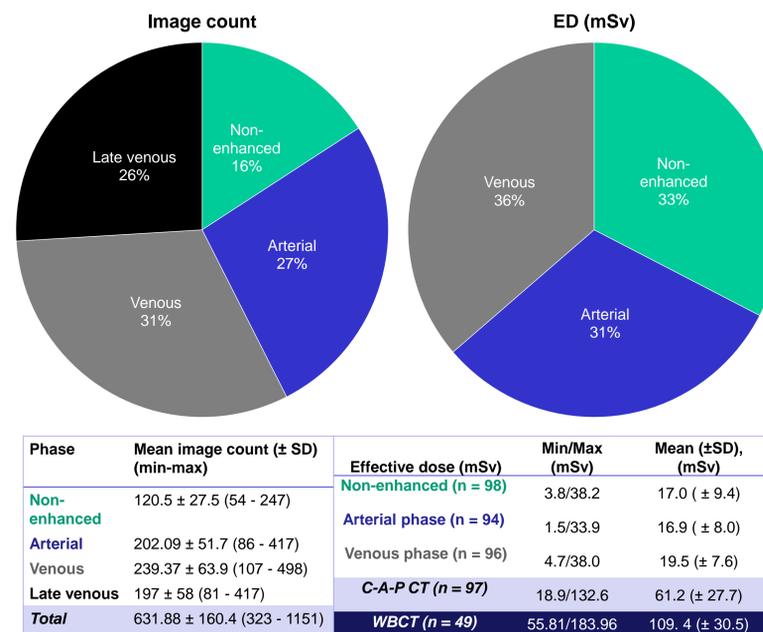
CT scan phase contribution to the workload (expressed as a number of images), and the radiation dose. Patients exposed to 109.4 (± 30.5) mSv had the cancer morbidity risk of 0.5% or 1/167.
